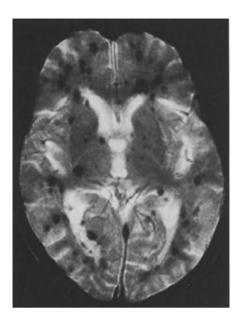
Axial MRI (TR FFE 500 ms, TE 35 ms), showing numerous little intraparenchymatous hypointense "cryptic" vascular lesions
